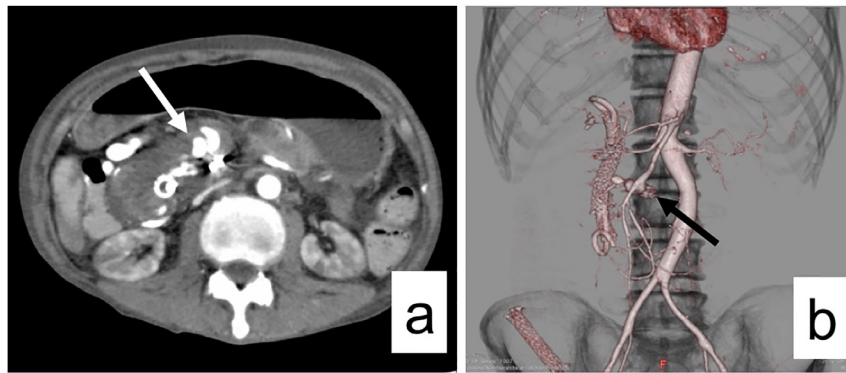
Contrast-enhanced computed tomography (CT) (a) CT showing an SMA pseudoaneurysm and extravasation leakage into the duodenum (white arrow) (b) 3D-CT clearly showing the anatomic position of the SMA pseudoaneurysm (arrow).
